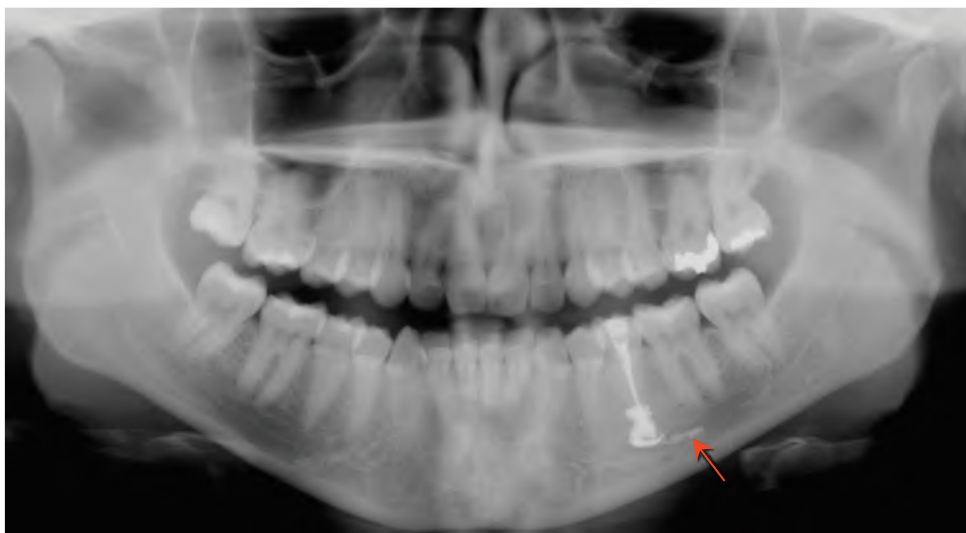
Panoramic radiograph of a patient complaining of pain and paresthesia/dysesthesia of the left side of the mandible and lower lip, shortly after root canal treatment. Note extrusion of radiopaque material into the inferior alveolar canal, extending several millimeters posteriorly (red arrow). This can explain the patient's chief complaint and neuropathic pain. Clinical symptoms correlated with radiographic findings. (Courtesy of Dr. Parish P. Sedghizadeh, Los Angeles, CA.)
